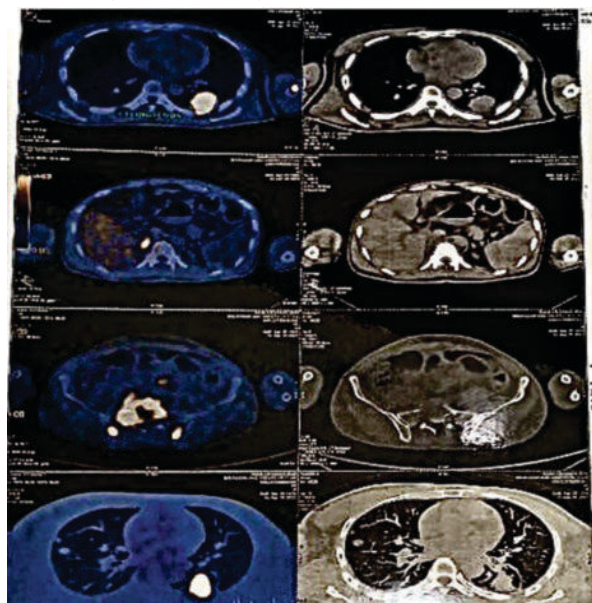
6 PET-CT scan showing active left lung primary tumor, bilateral pulmonary metastases, right adrenal metastasis and multiple skeletal metastases with impending fracture in proximal left humerus.
